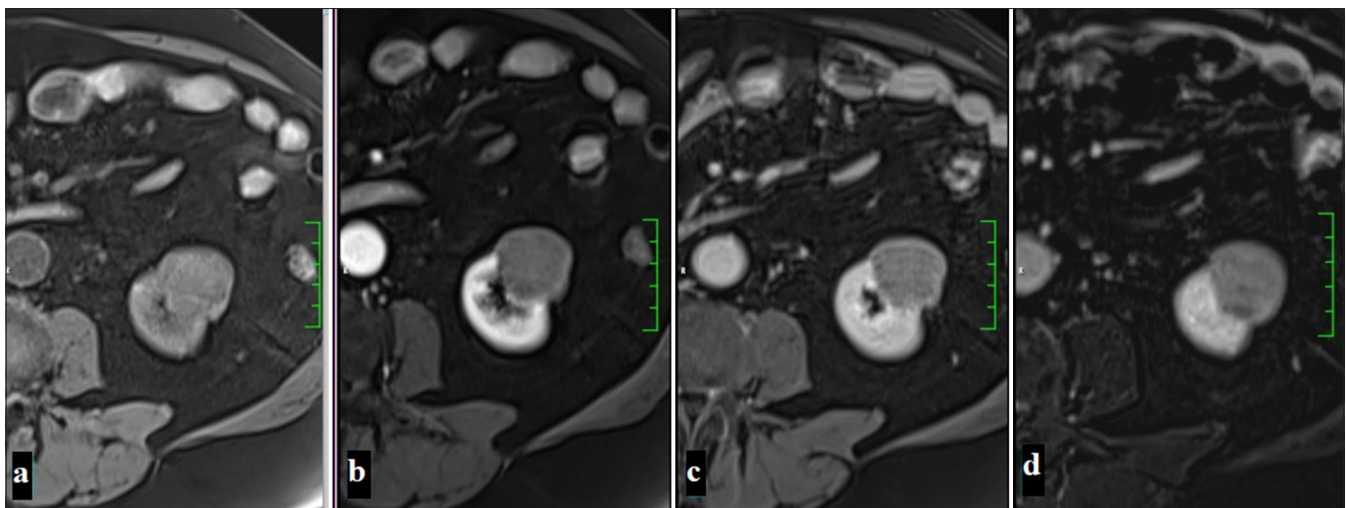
A 54-year-old man with a lesion observed as hypointense in precontrast fat-suppressed T1-weighted imaging (a), showing no significant contrast enhancement in the corticomedullary phase (b) and nephrogenic phase (c), with the subtraction image (d) confirming the absence of contrast enhancement (Papillary renal cell carcinoma).
